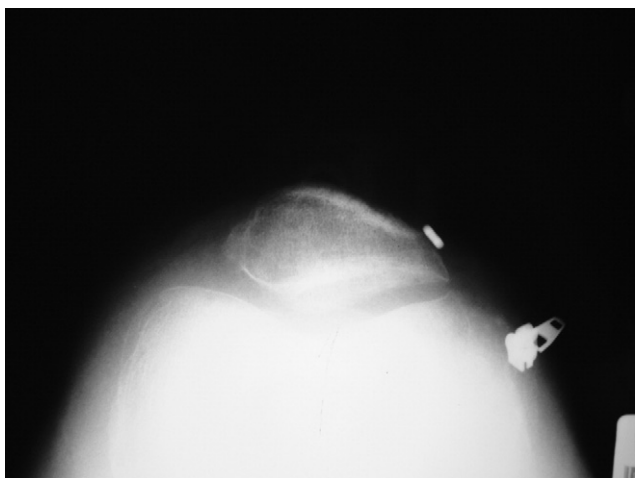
Sunrise radiograph demonstrating the use of a cortical button for patellar graft fixation.
